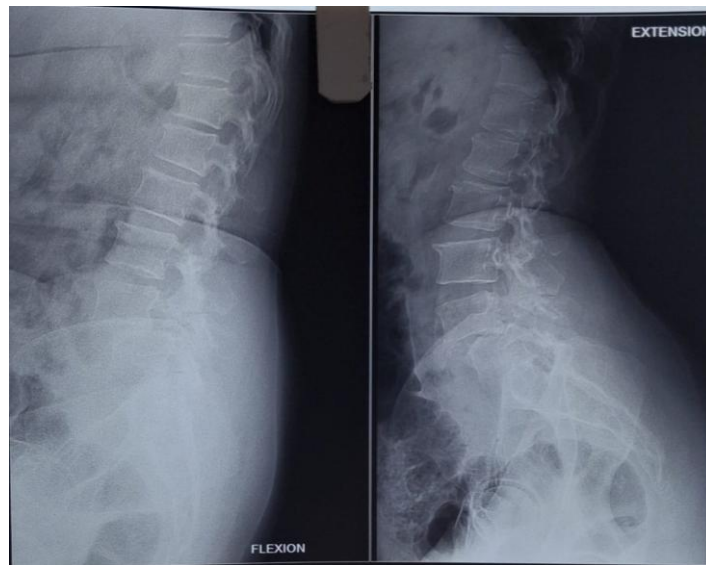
Pre-operative X-ray Lateral _ Flexion & Extension views
